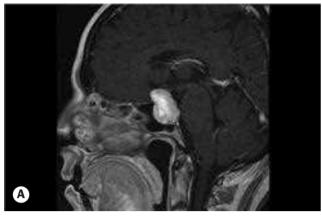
T1-weighted gadolinium-enhanced MR of a pituitary adenoma expanding the pituitary fossa and compressing the optic chiasm. (A) Sagittal and (B) coronal images
